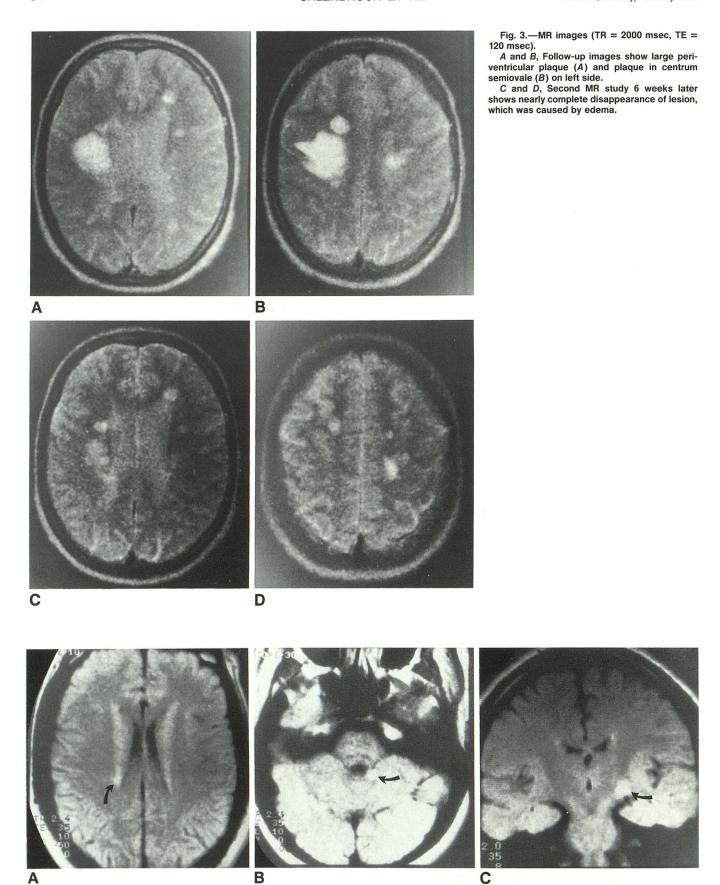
MR images (TR = 2000 msec, TE = 120 msec) in patient with severe physical disabilities and seizures. Only three plaques were found, one periventricular (A), one in cerebellar peduncle (B), and one at mesencephalon (C) (arrows).
